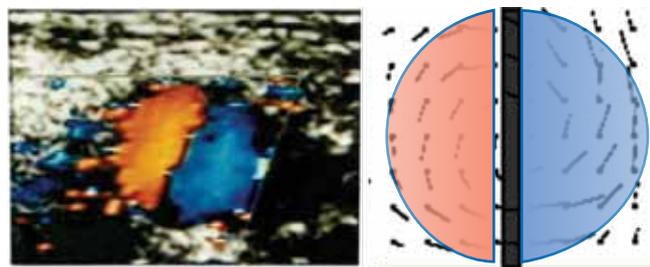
Arterial color Doppler of a transverse view of the common femoral artery and a graphic representation.
